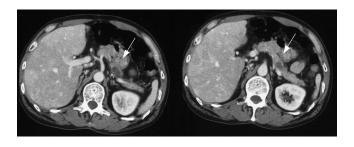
Case No. 2: A 54-yr-old patient with a diagnosis of IPMN in the body of the pancreas. CT scan. The cystic dilatation of the branch duct with protrusive lesions in the body of the pancreas. The main pancreatic duct is not dilated.
